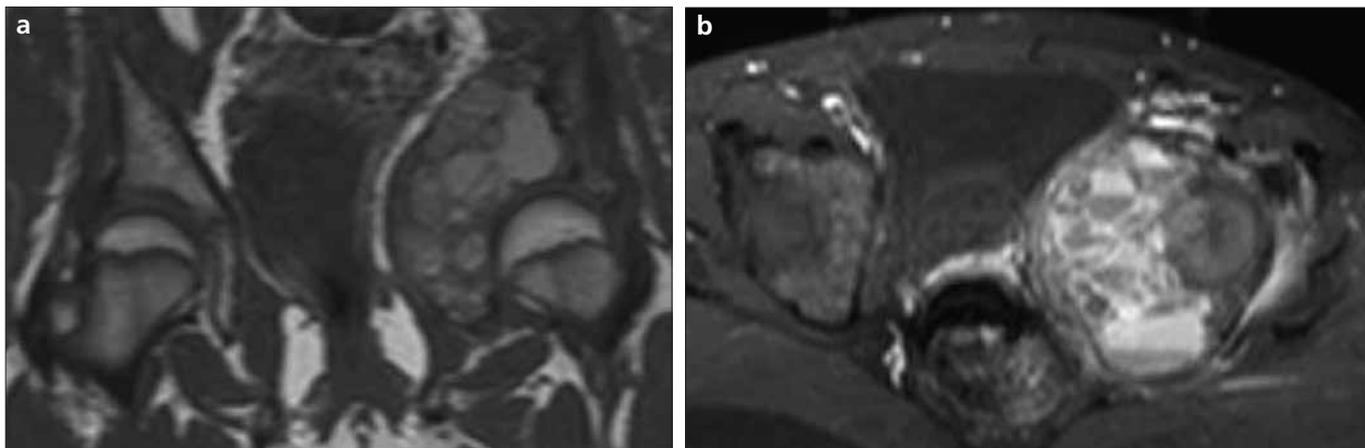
a, b. Coronal T1-weighted MR image (a) shows an expansile, lobulated, multiseptated, cystic mass on the left acetabulum. The mass has fluid-fluid levels hyper- and isointense with regard to muscles. Post-contrast axial fat saturated T1-weighted MR image (b) shows prominent enhancement of the lesion.
